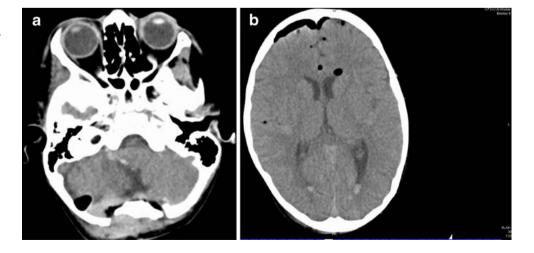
a Post-operative CTscan of brain showing craniotomy site. b Post-operative CT scan of brain showing minimal blood in the occipital horns
